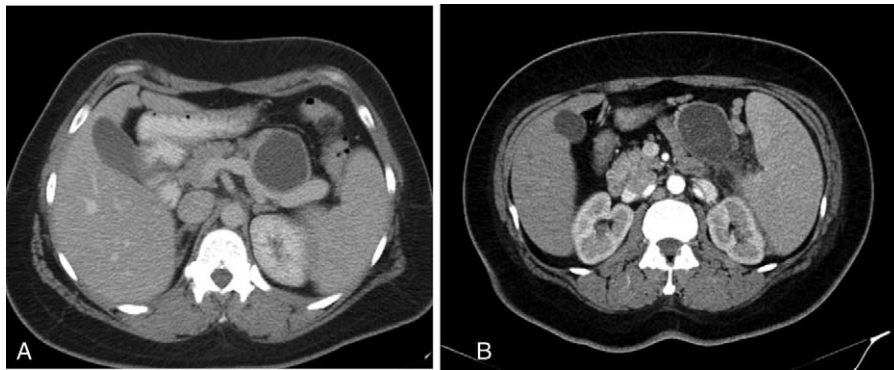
Abdominal CT. January 2015: Incidental finding of a pancreatic cystic lesion located in the tail of the pancreas, well defined, with patent splenic vein and normal-sized spleen (A). January 2017: enlargement of the cystic lesion, with internal enhanced septa and wall (B).
